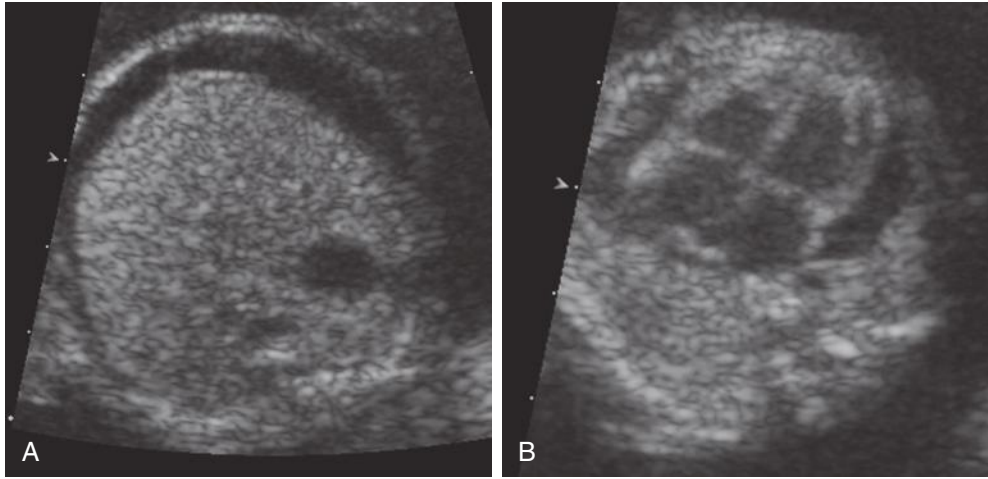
Parvovirus infection. Ascites (A) and pericardial effusions (B) in a fetus with anemia due to parvovirus infection. Fetal ascites is often the initial sonographic finding in parvovirus infection.
